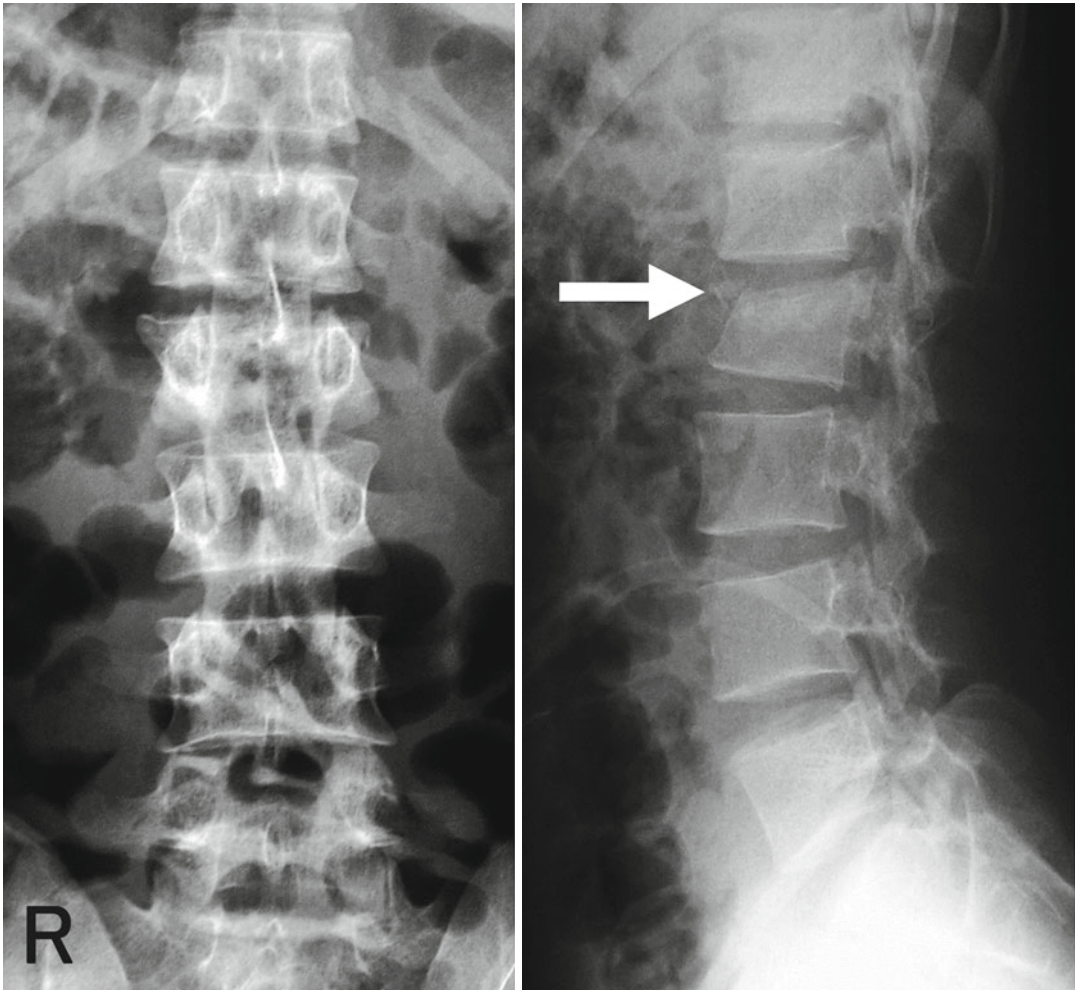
Anteroposterior and lateral X-ray
